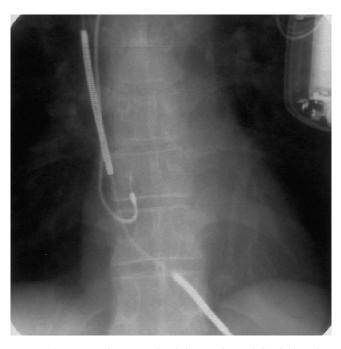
X-ray photograph of the implanted dual-chamber ICD Phylax AV (Biotronik) with a shock lead in the right ventricular apex and a pacing lead in the lateral part of the right atrium.
